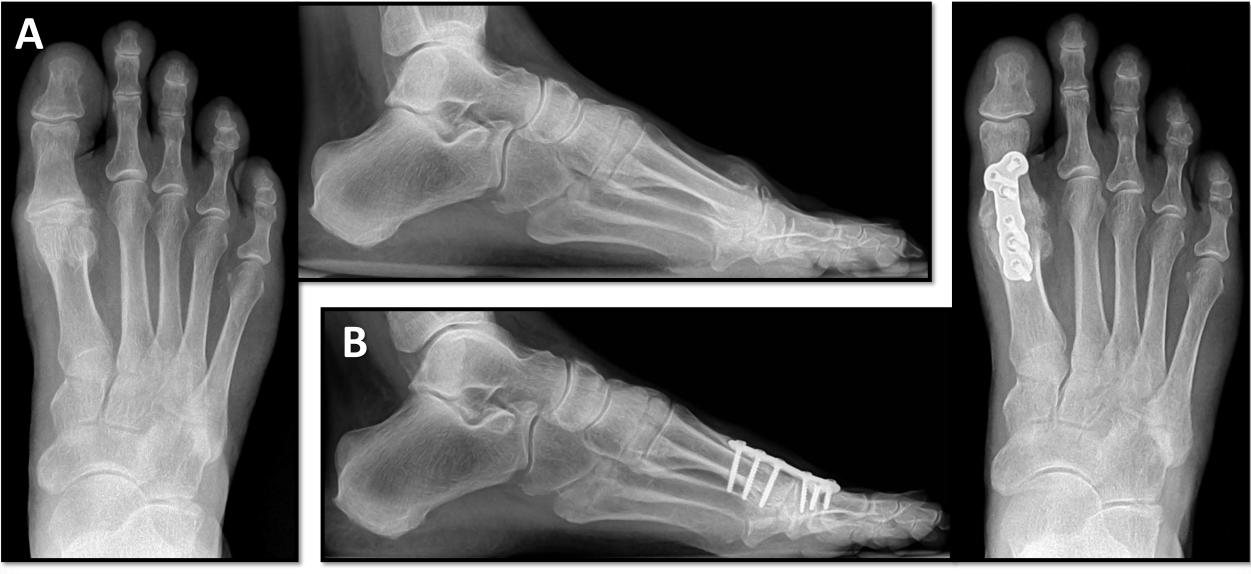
A) Pre-operative AP and Lateral radiographs of patient with HR. B) Postoperative AP and Lateral radiographs.
